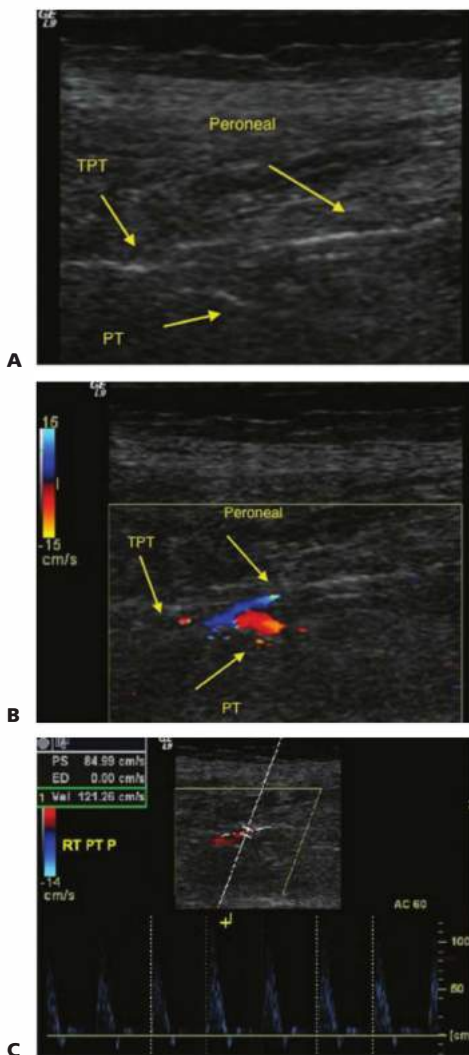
• A. Duplex B-mode image shows the calcified tibio-peroneal trunk bifurcation into the posterior tibial artery and peroneal artery. B. Duplex of the tibio-peroneal trunk bifurcation shows flow into the posterior tibial artery. C. Duplex of the proximal posterior tibial artery shows normal triphasic Doppler waveform.
